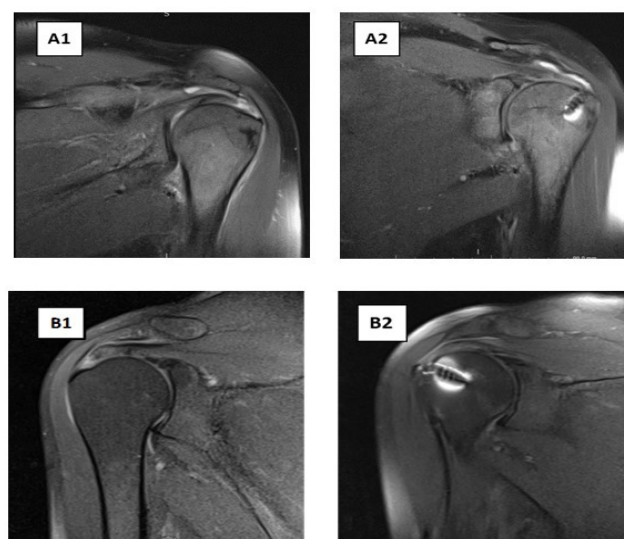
Preoperative (A1 and B1) and postoperative (A2 and B2) MR images of the patients
